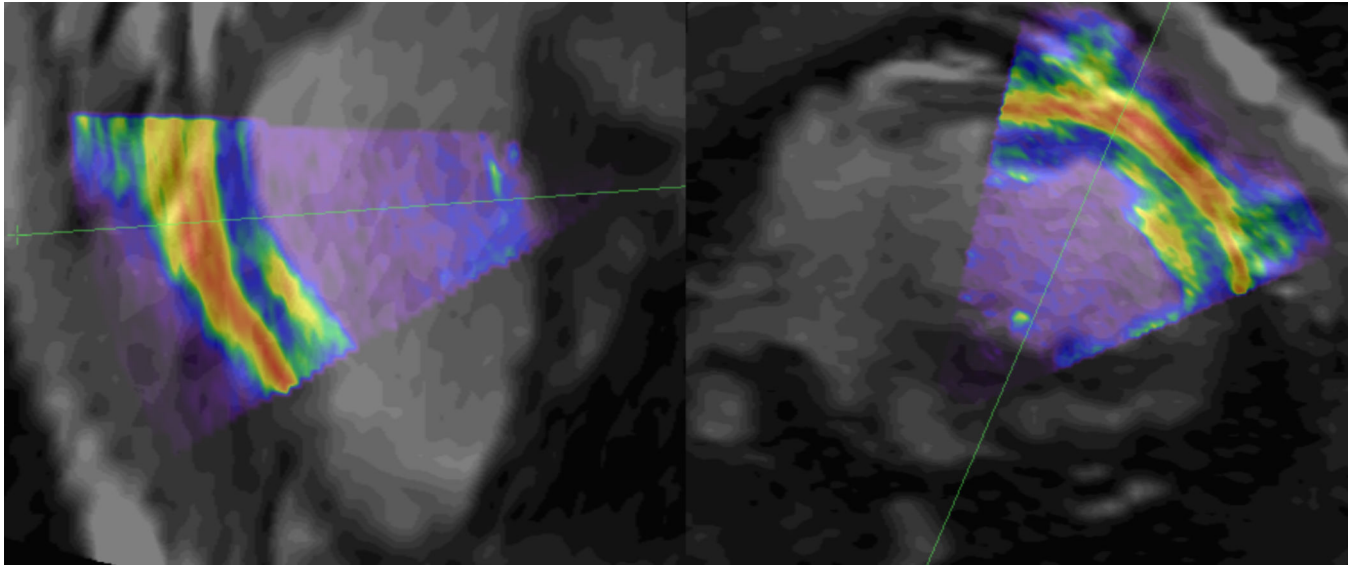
Long (left) and short (right) axis slices of the pre-operative MR image (grayscale) with overlaid 3DEcho (colored). Notice the general agreement between anatomical features in the two images. The green lines reveal the location of the image slice in the other view.
